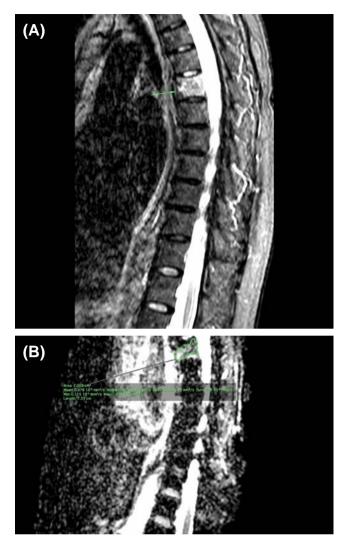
Short tau inversion recovery (STIR) sequence and acquisition of apparent diffusion coefficient (ADC) values of spine magnetic resonance imaging (MRI). (A) Spondylitis on STIR MRI of spine. (B) Acquisition of ADC values from ADC map
